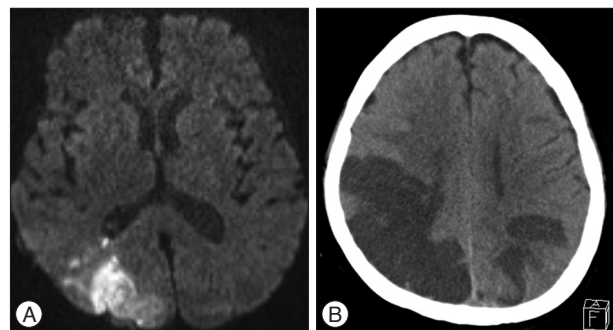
MRI diffuse weighted (A) and CT (B) images showing acute infarction in the both occipital lobes.
